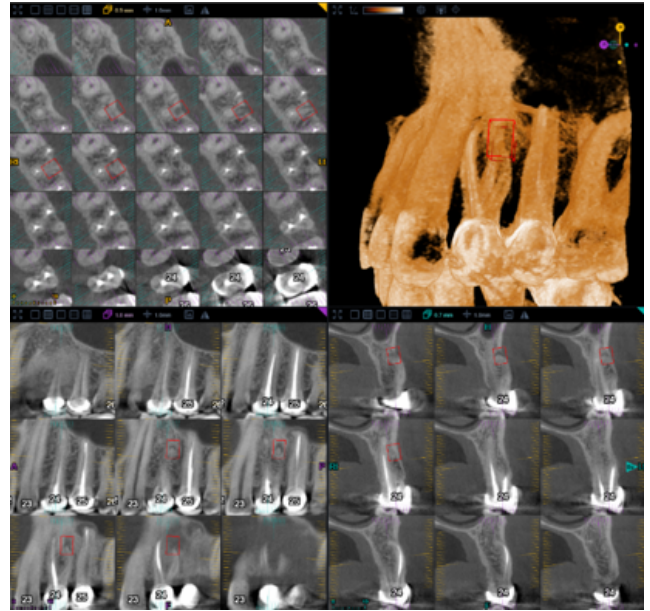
Three-dimensional cone-beam computed tomographic (CBCT) images of tooth #24 showing three distinct roots
